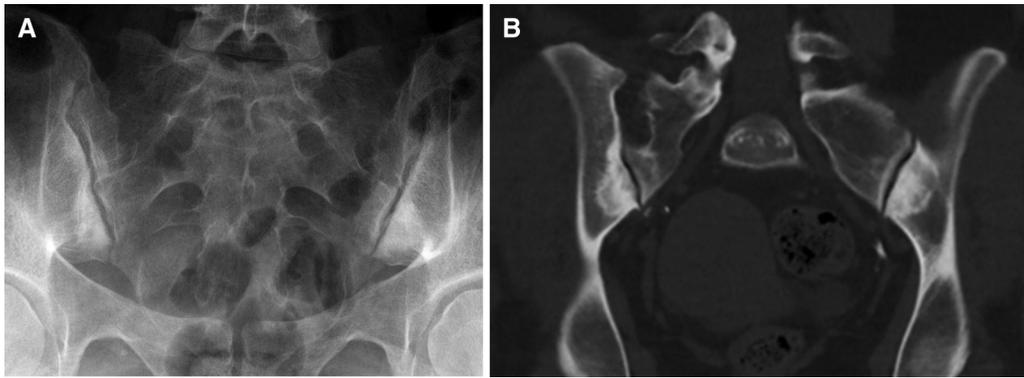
Osteitis condensans ilii. (A) Pelvic radiograph in a middle age female shows triangular areas of sclerosis along the inferior iliac margins of the sacroiliac joints without joint erosion or widening. (B) Coronal computed tomography with bone windows confirms radiographic findings, consistent with osteitis condensans ilii.
